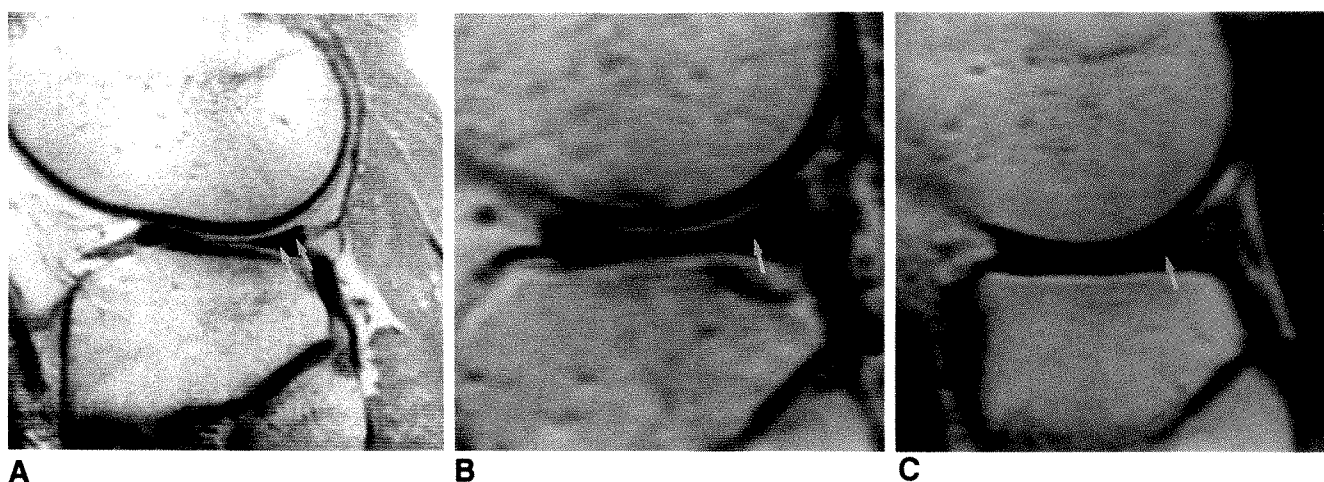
A-C, Three examples of T1-weighted (600/25) MR images showing equivocal tears of posterior horn of lateral meniscus (arrows). Linear areas of signal in meniscus do not definitely extend through inferior surface. No tears were found at arthroscopy.
